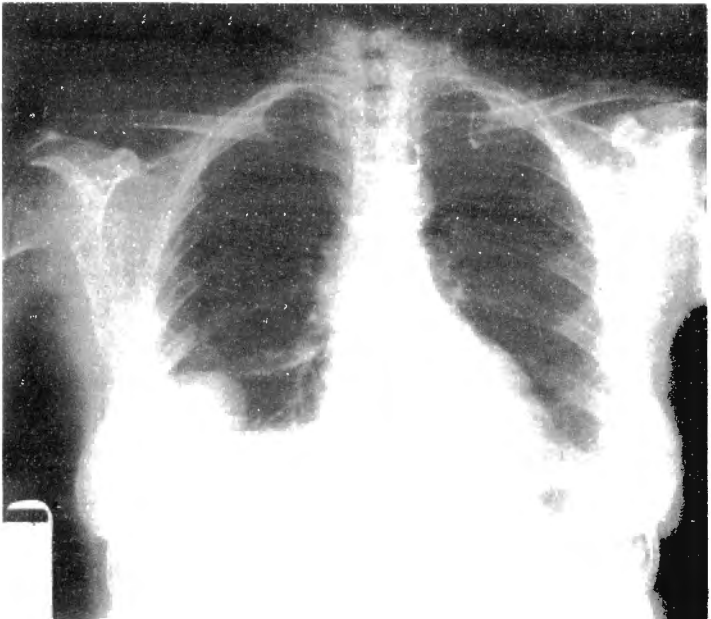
Radiograph showing a mass on the right lower lobe. Hamartoma of the lung in a patient from Sanhıdır.
